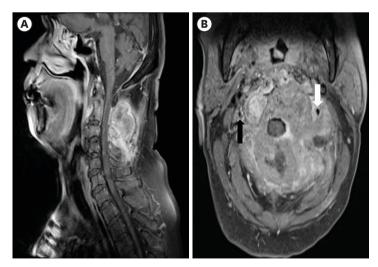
Pre op T1-weighted enhanced magnetic resonance imaging. (A) Enhanced mass involving C1-2 posterior elements extending into the posterior neck muscles on T1-weighted enhanced magnetic resonance imaging. (B) The left vertebral artery slightly deviated toward lateral side and was encased by a tumor (white arrow), normal right vertebral artery (black arrow).
